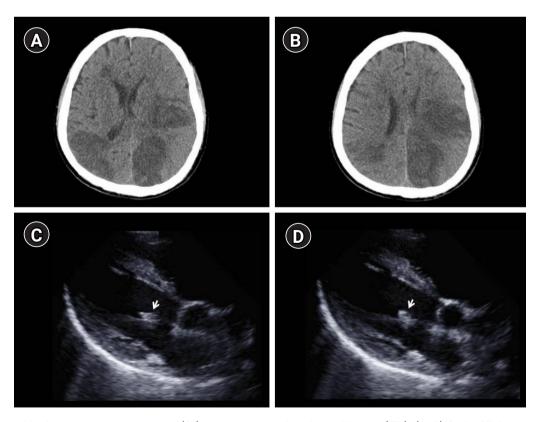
Findings of brain computed tomography (CT) and transthoracic echocardiogram (TTE). (A, B) Brain CT demonstrates multiple hypodense lesions with surrounding edema in different areas of the brain. (C, D) In the TTE (supine view), a mobile and irregularly shaped echodense mass of approximately 1.0×0.5 cm is attached to the anterior mitral valve (white arrows).
